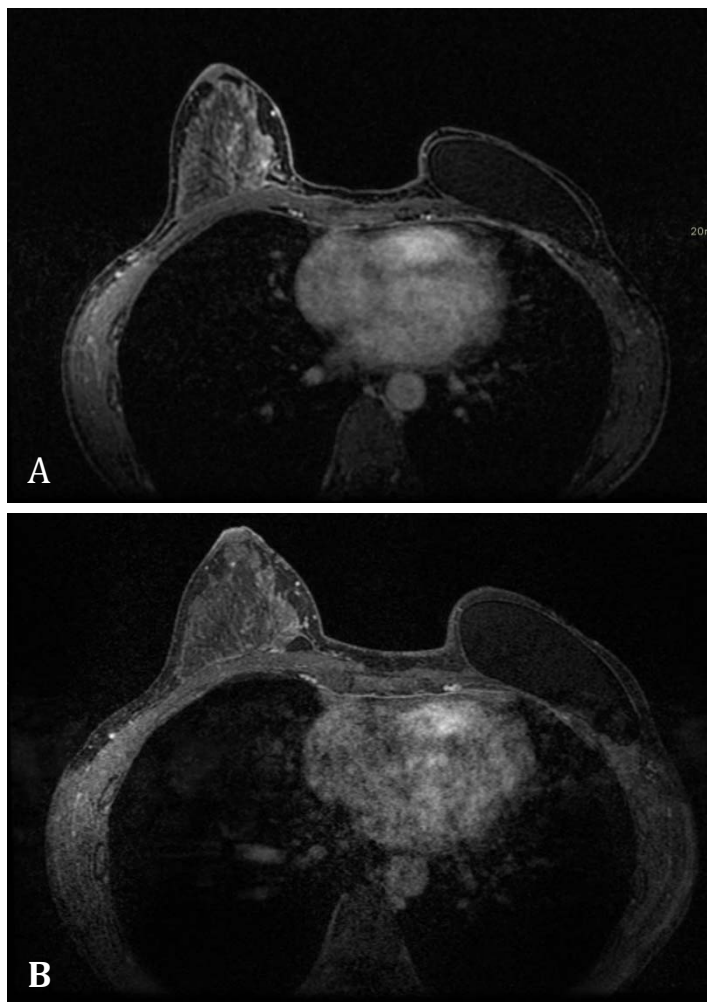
43-year-old woman with history of breast DCIS s/p left mastectomy, presents for high risk screening. (A) Axial contrast enhanced DISCO T-1 Weighted MRI showed a probably benign BIRADS-3 lesion, an enhancing 5 mm focus in the medial right breast skin adjacent to a skin lesion, and a focus close to the chest wall within dense tissue. (B) Follow-up breast MRI in 6 months showed a previously noted right breast skin lesion has resolved and there is no change in the benign appearing focus, while the second focus near the chest wall has resolved.
